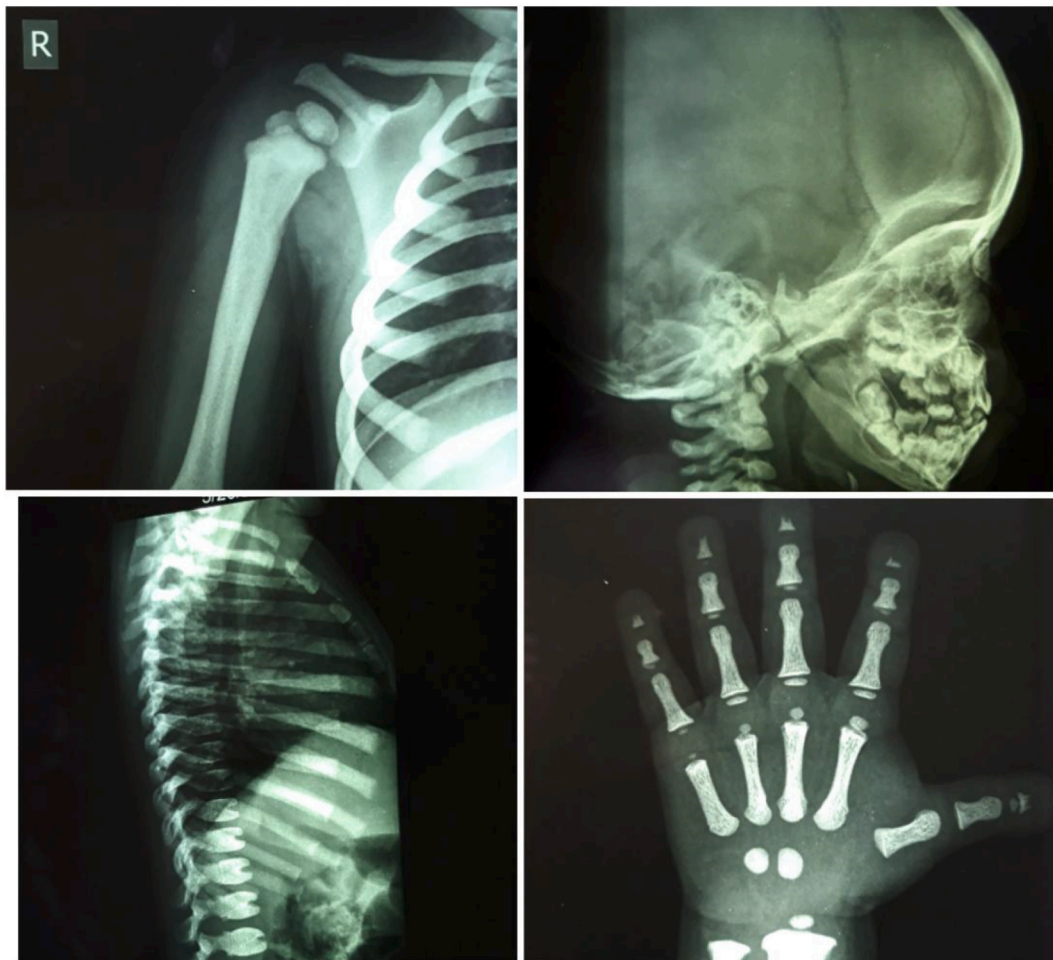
Radiography manifestations in different views.
